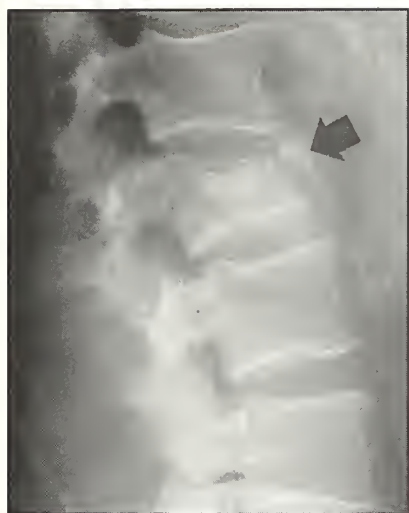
Lateral radiograph showing greater than 50% anterior column collapse in an L2 burst fracture.
